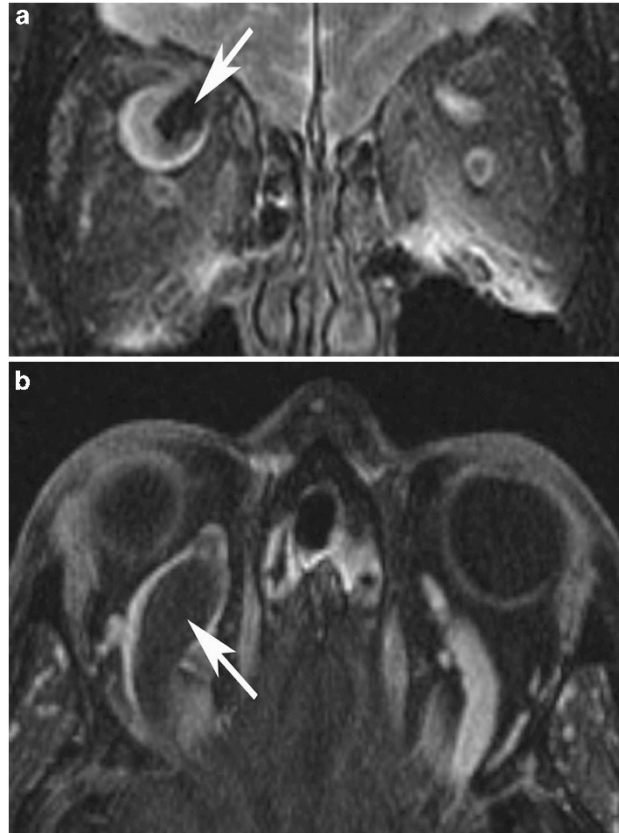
(a and b) Case 2. Axial and coronal MRI and MRV showing bilaterally enlarged SOV, more pronounced on the right with intraluminal thrombus (arrow).
